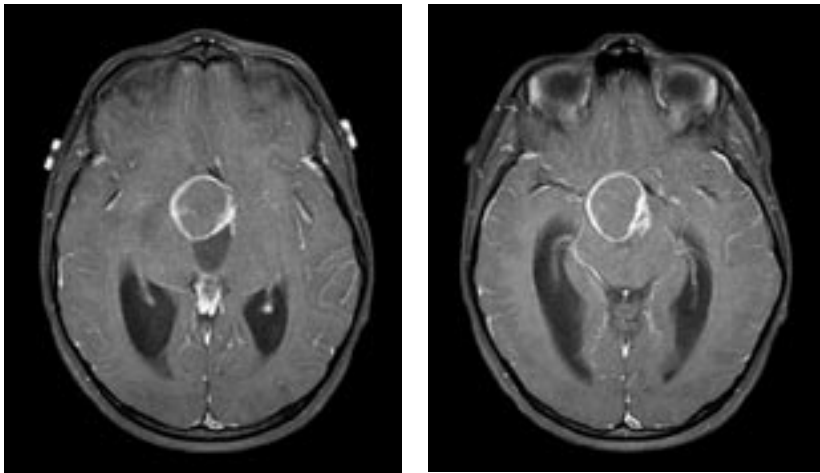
Craniopharyngioma in an 8-year-old boy presenting with visual disturbance and headaches. MRI demonstrated a contrast-enhancing cystic lesion in the suprasellar cistern with obstructive hydrocephalus.
